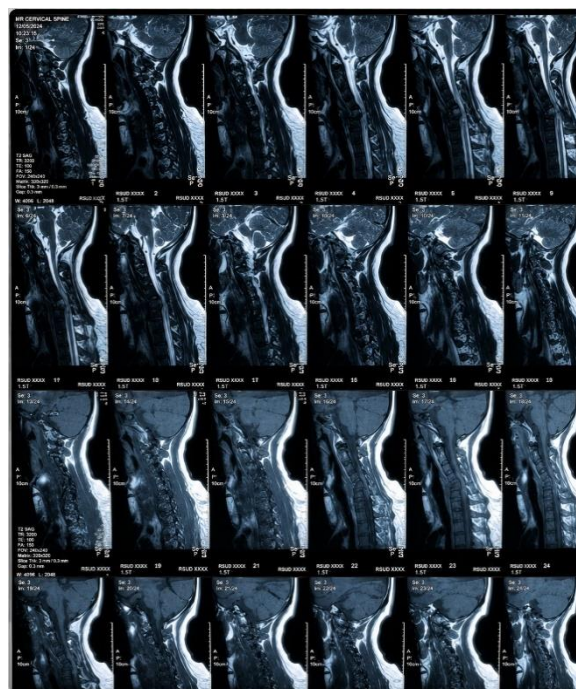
Cervical MRI demonstrating C5 burst fracture with retrolisthesis, posterior ligament sprain, C4-C6 myelopathy and hematoma, and C5-C6 disc bulging with annular tear leading to moderate canal and foraminal stenosis.
